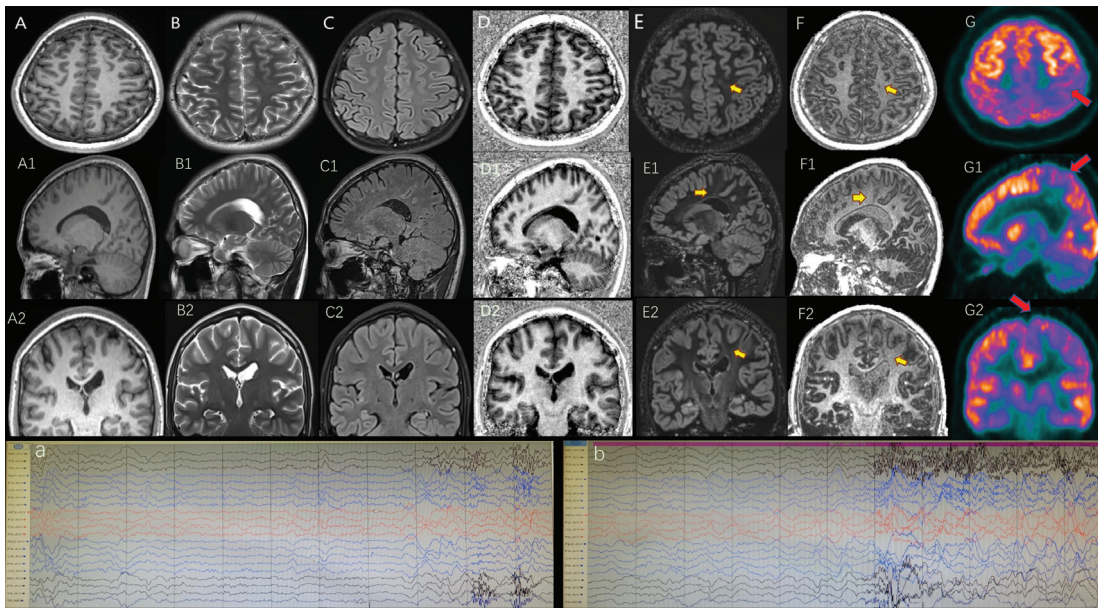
Comparison between different MRI sequences (A–A2) transverse, sagittal, and coronal views of MPRAGE, (B–B2) T2-TSE, (C–C2) T2-FLAIR, (D–D2) MP2RAGE, (E–E2) DIR, (F–F2) 3D-EDGE imaging. Subcortical hypointense with a transmantle sign is seen only at the 3D-EDGE sequence (arrows in F–F2). Based on the lesions found on 3D-EDGE sequence imaging, reviewed the other MRI sequences carefully, and DIR sequence indicates that there is a subtle fuzzy abnormal signal at the same level of lesions (arrows in E–E2). On the FDG-PET, there was extensive hypometabolism in the left parietal lobe area (arrows in G). (a), interictal EEG. Note spike waves over the left central-parietal area. (b) Ictal EEG associated with myoclonic jerks. 3D-EDGE, three-dimensional edge-enhancing gradient echo; EEG, electroencephalography; FDG-PET, fluorodeoxyglucose–positron emission tomography; FLAIR, fluid-attenuated inversion recovery; MPRAGE, magnetization-prepared rapid acquisition gradient echo MRI, magnetic resonance imaging; MP2RAGE, magnetization-prepared 2 rapid acquisition gradient echo; TSE, transmissible spongiform encephalopathies.
